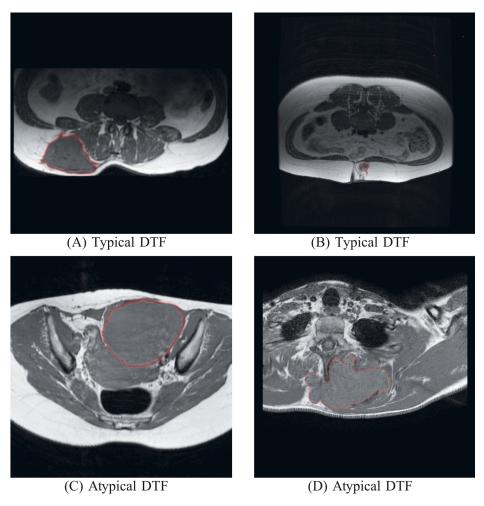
The typical examples (A and B) are two cases always classified correctly by the T1-weighted (T1w) imaging model; the atypical examples (C and D) are two cases always classified incorrectly by the T1w imaging model.
